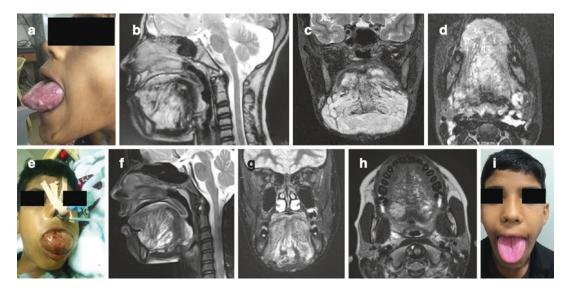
A 10-year-old male presented with swelling in the tongue causing difficulty in eating, breathing. There is macroglossia causing speech difficulty and glossoptosis. (a) Clinical photograph on presentation showing macroglossia with prominent reddish papule over the tongue. (b, c, d) Preoperative magnetic resonance imaging sagittal section showing T2 hyperintense lesion with septa involving the tongue in its entirety and the floor of the mouth. The lesion is causing airway compromise. The findings are suggestive of microcystic lymphatic malformation. Bleomycin sclerotherapy was done with prior intubation. 0.5 cc of diluted bleomycin solution was injected in the anterior part of the tongue. The swelling started increasing immediately after injection to the extent that compression was not stopping the bleeding from the puncture site.
